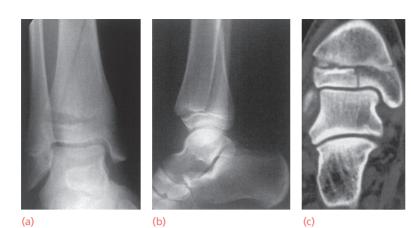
Triplane fracture The three fracture planes may not be seen in a single X-ray, but can be visualized from a combination of images (a,b). In this case the epiphyseal fracture is clearly seen only in the coronal plane CT scan (c).
